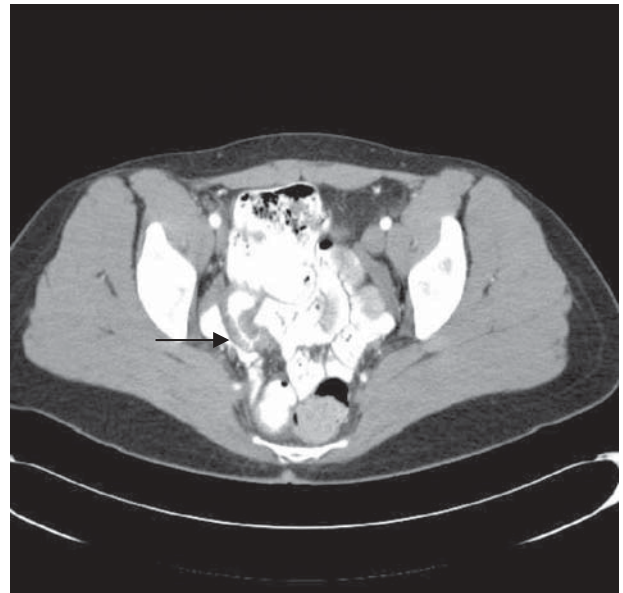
Computed tomographic imaging showing thickening of terminal ileum
